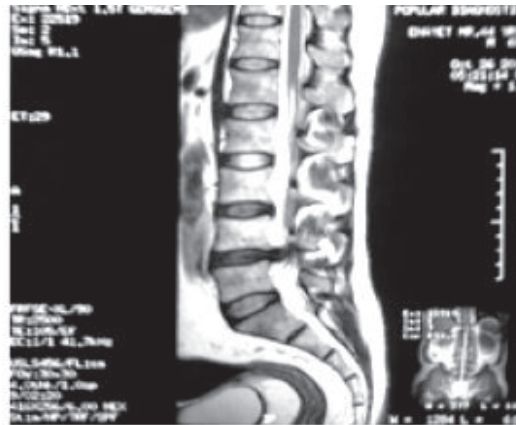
MRI of lumbosacral spine T2 weighted sagittal view showing disc prolapsed at L4-5.
